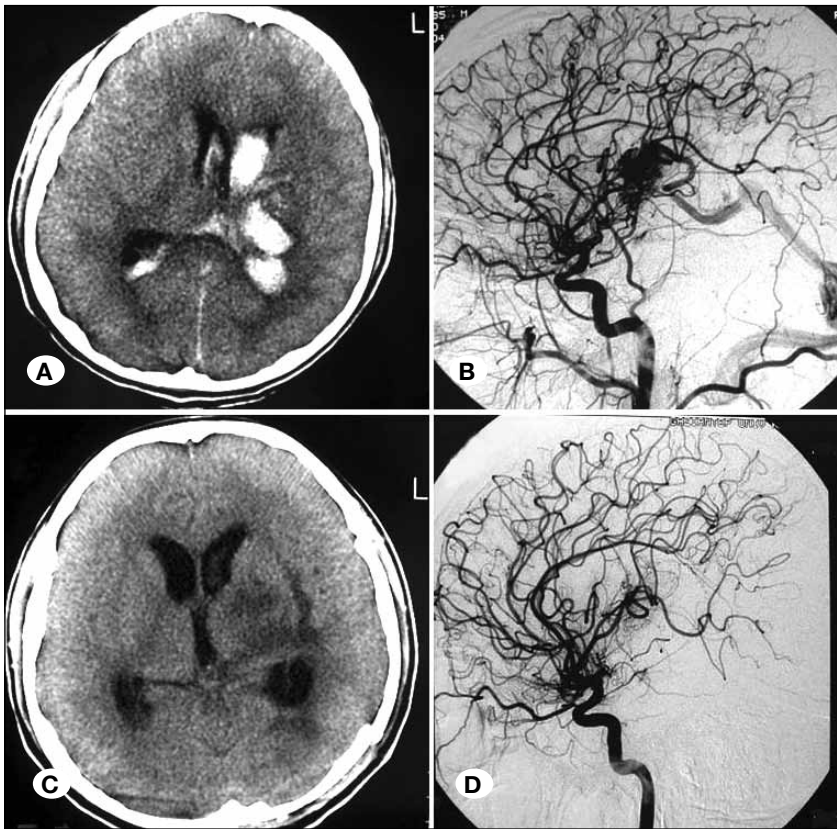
Computerized tomography of the brain revealed an intracerebral haemorrhage in left diencephalic structures opening to the lateral ventricles, which was thought to be an AVM as the patient was 19 years old (A). The plexiform AVM had a single feeder from the left lenticulostriate artery and a single vein draining to the Galenic system (B). A postoperative control CT scan taken 2 months after the operation revealed total resection of the AVM (C) and DSA also confirmed total resection of the lesion (D).
